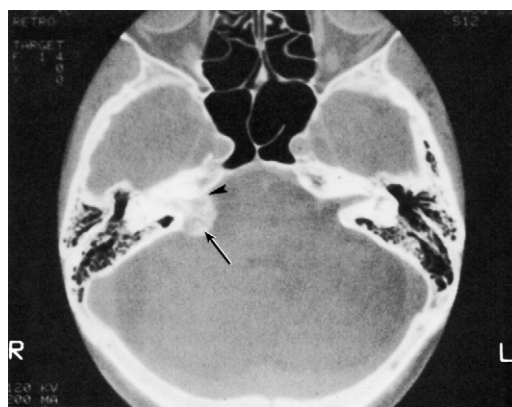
Meningioma of the internal auditory canal (IAC). Computed tomography scan on a bone algorithm shows a calcified mass protruding from the IAC (*arrow*). Because this lesion arises from the IAC the junction between the lesion and the posterior wall of the petrous bone is more acute (*arrowhead*).
